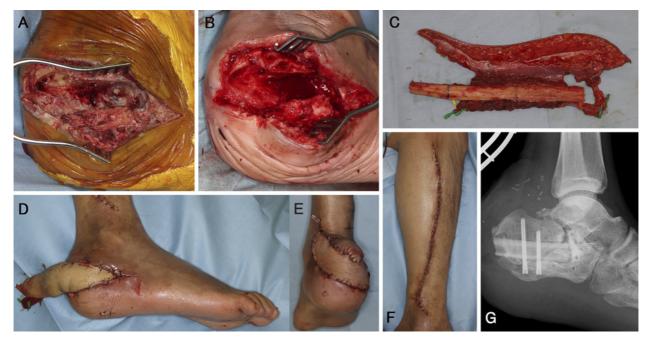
Intraoperative views. (A) After residual artificial and decayed bone were removed entirely; (B) after trabecular bone (the weight was 9.8 g) was filled into the resulting defect; (C) the elevated free fibular osteocutaneous flap; (D) the vascularized bone (the length was 4 cm) fixed by two compression screws and the flap sutured on the lateral side of the heel; (E) after vascular anastomosis was finished and the flap was fixed; (F) the donor site was sutured and closed; and (G) radiographic finding immediately after the operation.
